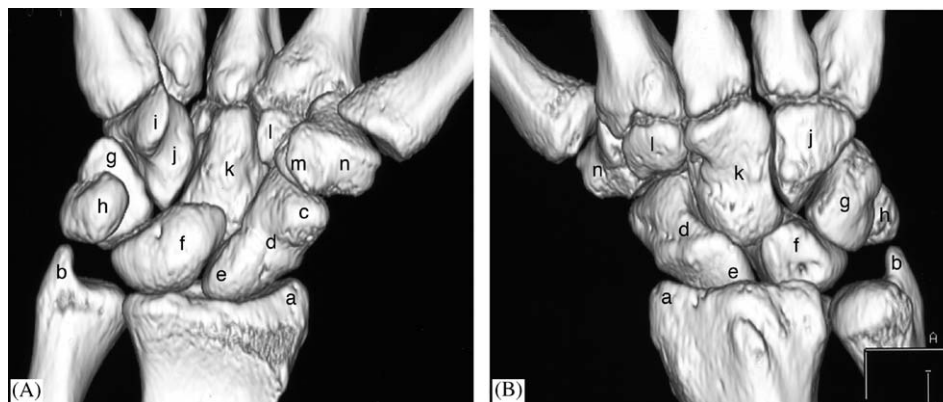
Palmar (A) and dorsal view (B) of the carpus describing the osteology. Landmarks on the 3D CT reconstruction are—(a) radial styloid, (b) ulnar styloid, (c) scaphoid tubercle, (d) waist of scaphoid, (e) proximal pole of scaphoid, (f) lunate, (g) triquetrum, (h) pisiform, (i) hook of hamate, (j) hamate, (k) capitate, (l) trapezoid, (m) tubercle of trapezium, (n) trapezium.
